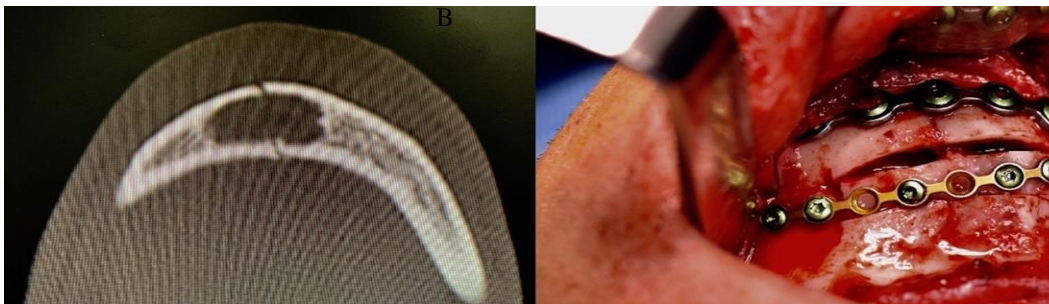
(A) Evidence of line fracture on CBCT of case 2. (B) Bone fixation after removing the cystic lesion in case 2.
